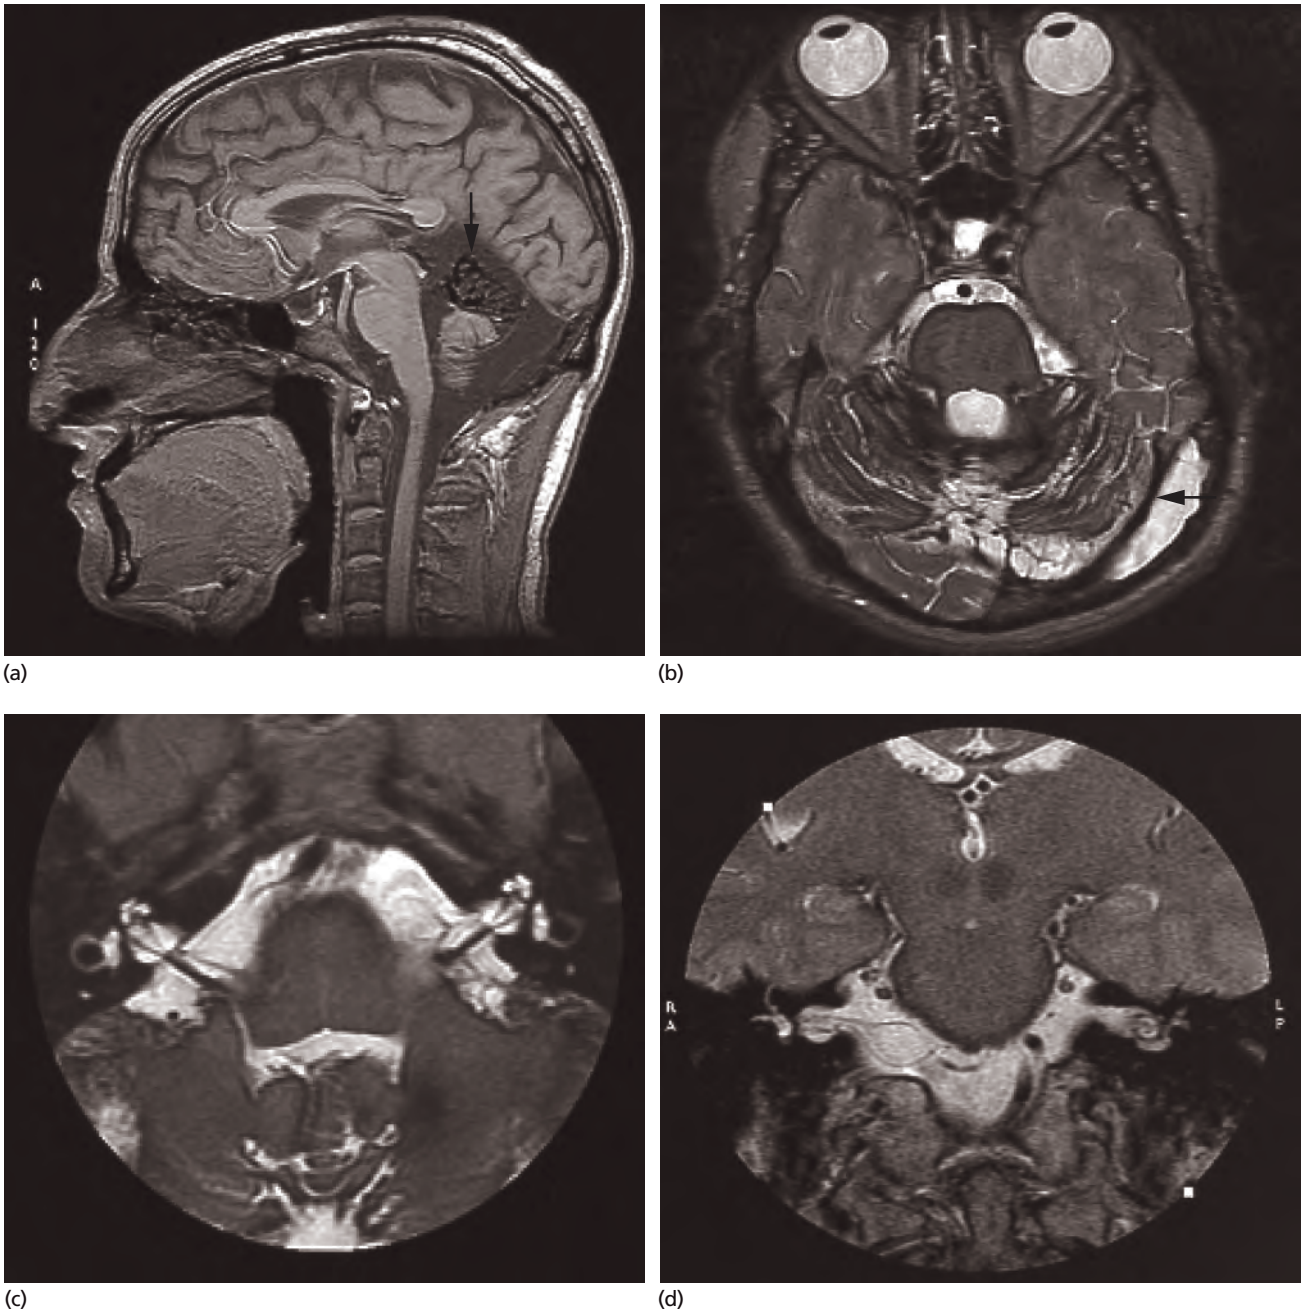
MR imaging of siderosis in a 38-year-old man with progressive tinnitus, deafness and ataxia (courtesy of Queen Square Imaging Centre). (a) Sagittal MR – hypointensity in cerebellum, with cerebellar atrophy. (b) T2W axial MRI – superficial hypointensity surrounding cerebellum. (c, d) T2W MRI – superficial hypointensity surrounding VIII and V.
